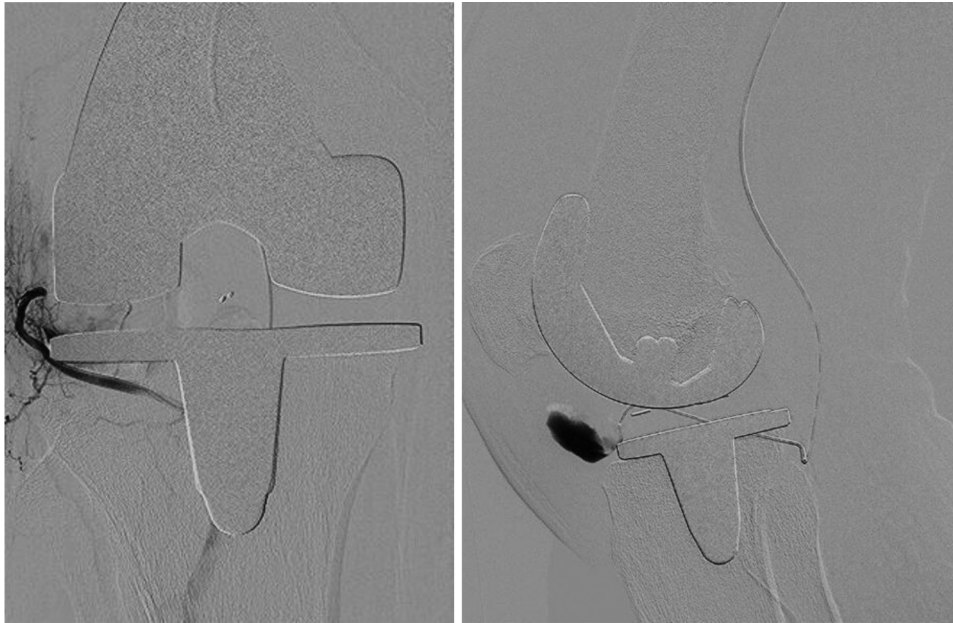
Computed tomography angiography on an anteroposterior (left) and a lateral (right) view showing a pseudoaneurysm of the inferior lateral geniculate artery of the right knee.
